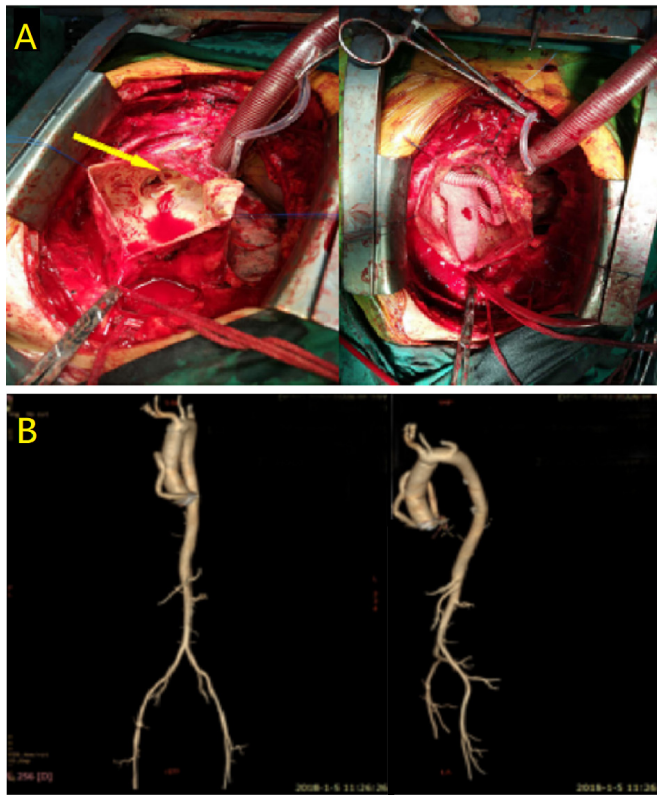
Intraoperative (A) and postoperative CTA examination (B)
